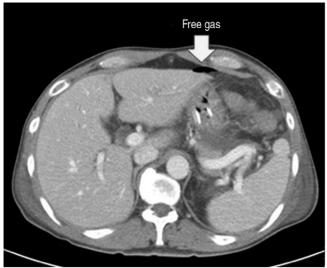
Free gas in abdomen-pelvic CT.
